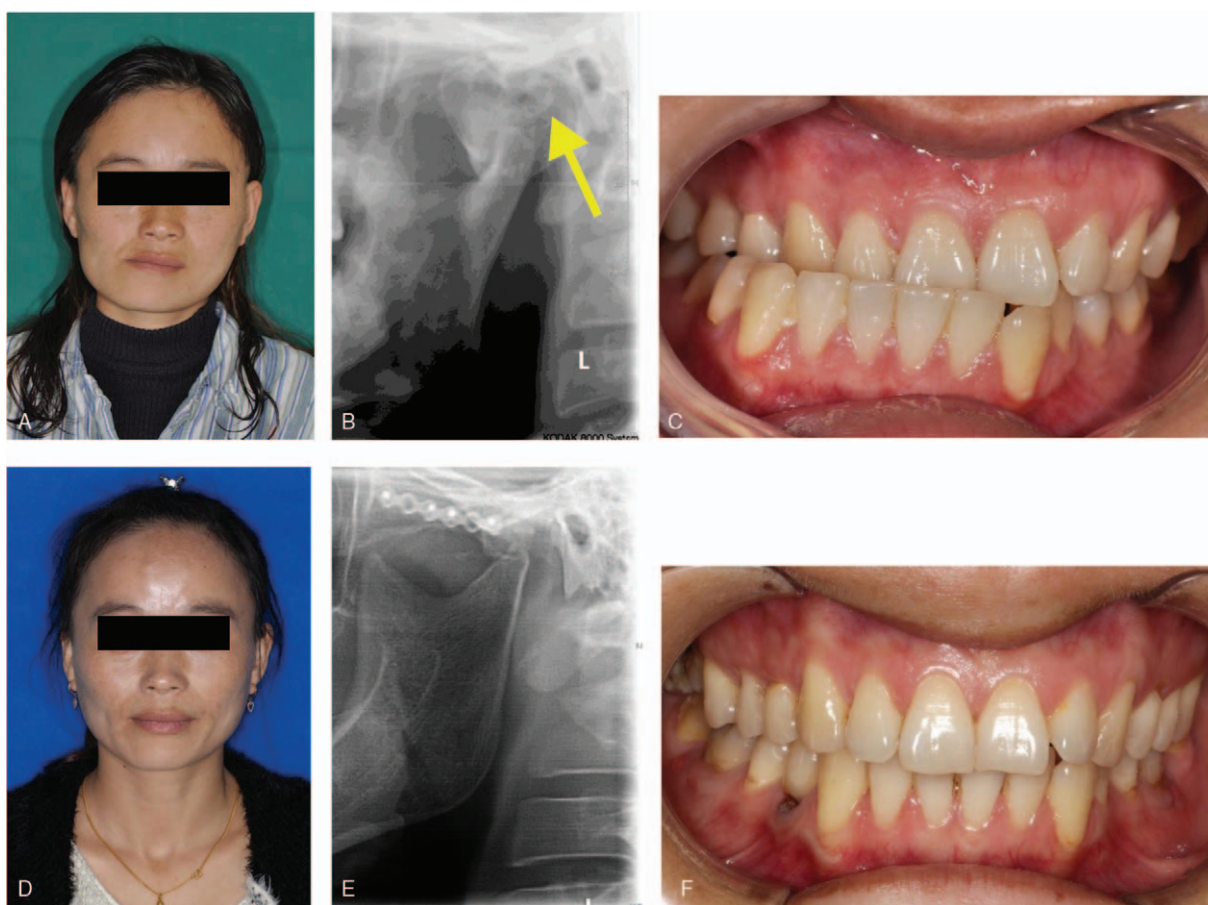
Preoperative and postoperative outcomes. (A) Frontal view showing elongation of the OC-affected side with mandible deviation to the contralateral side; (B) the panoramic radiograph showing a radiopacity located medial to the condyle (yellow arrow); (C) locked occlusion on the OC-affected side, and crossbite on the contralateral side; (D) improved facial appearance; (E) local resection of the OC using a transzygomatic approach; (F) stable occlusion after orthodontic traction. OC=condylar osteochondroma.
